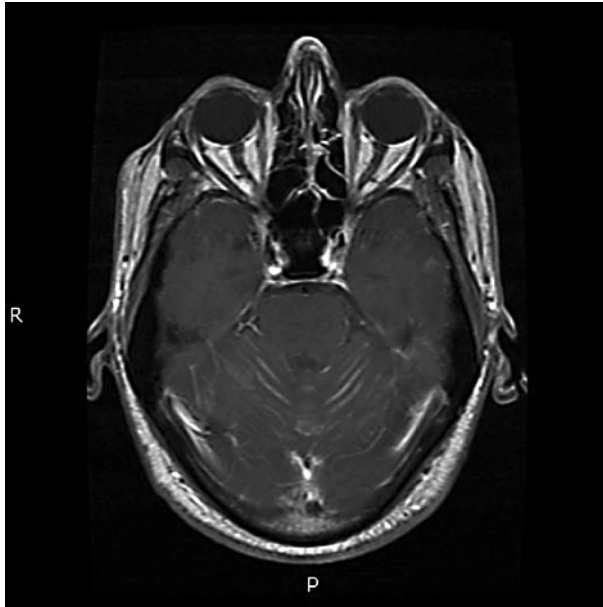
T₁-weighted gadolinium-enhanced MRI showing abnormal leptomeningeal enhancement patterns of the infratentorial compartment and the supratentorial basal cisterns.
